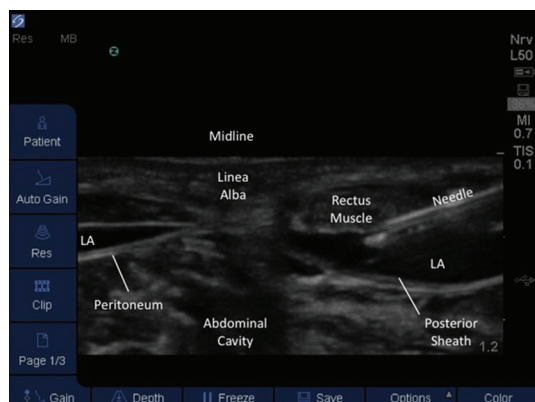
Rectus sheath block as seen by ultrasound. Probe in transverse position just superior to the umbilicus. LA: local anaesthetic.
